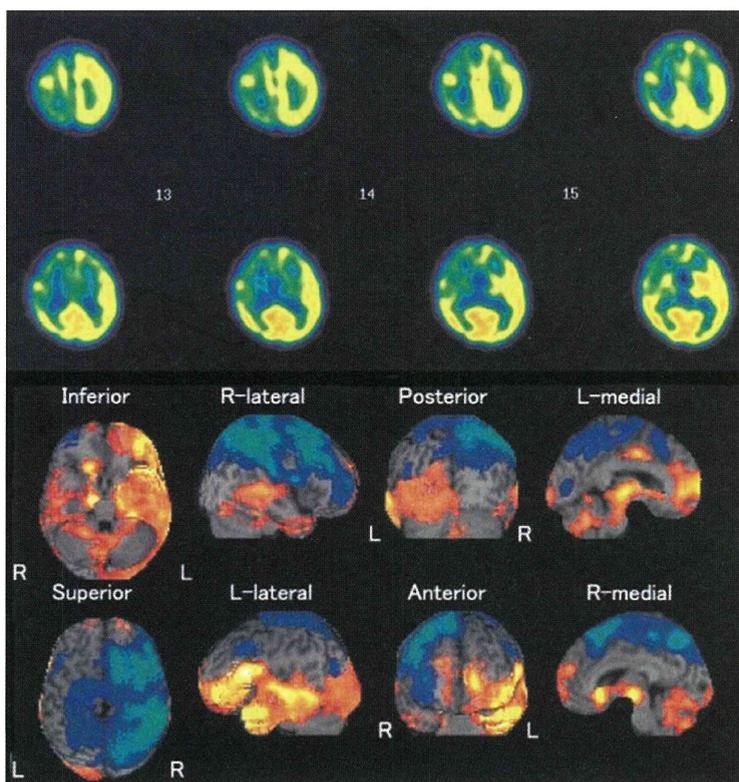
Single Photon Emission Computed Tomography (SPECT): hypoperfusion in frontal and temporal regions on day 10 after onset.
